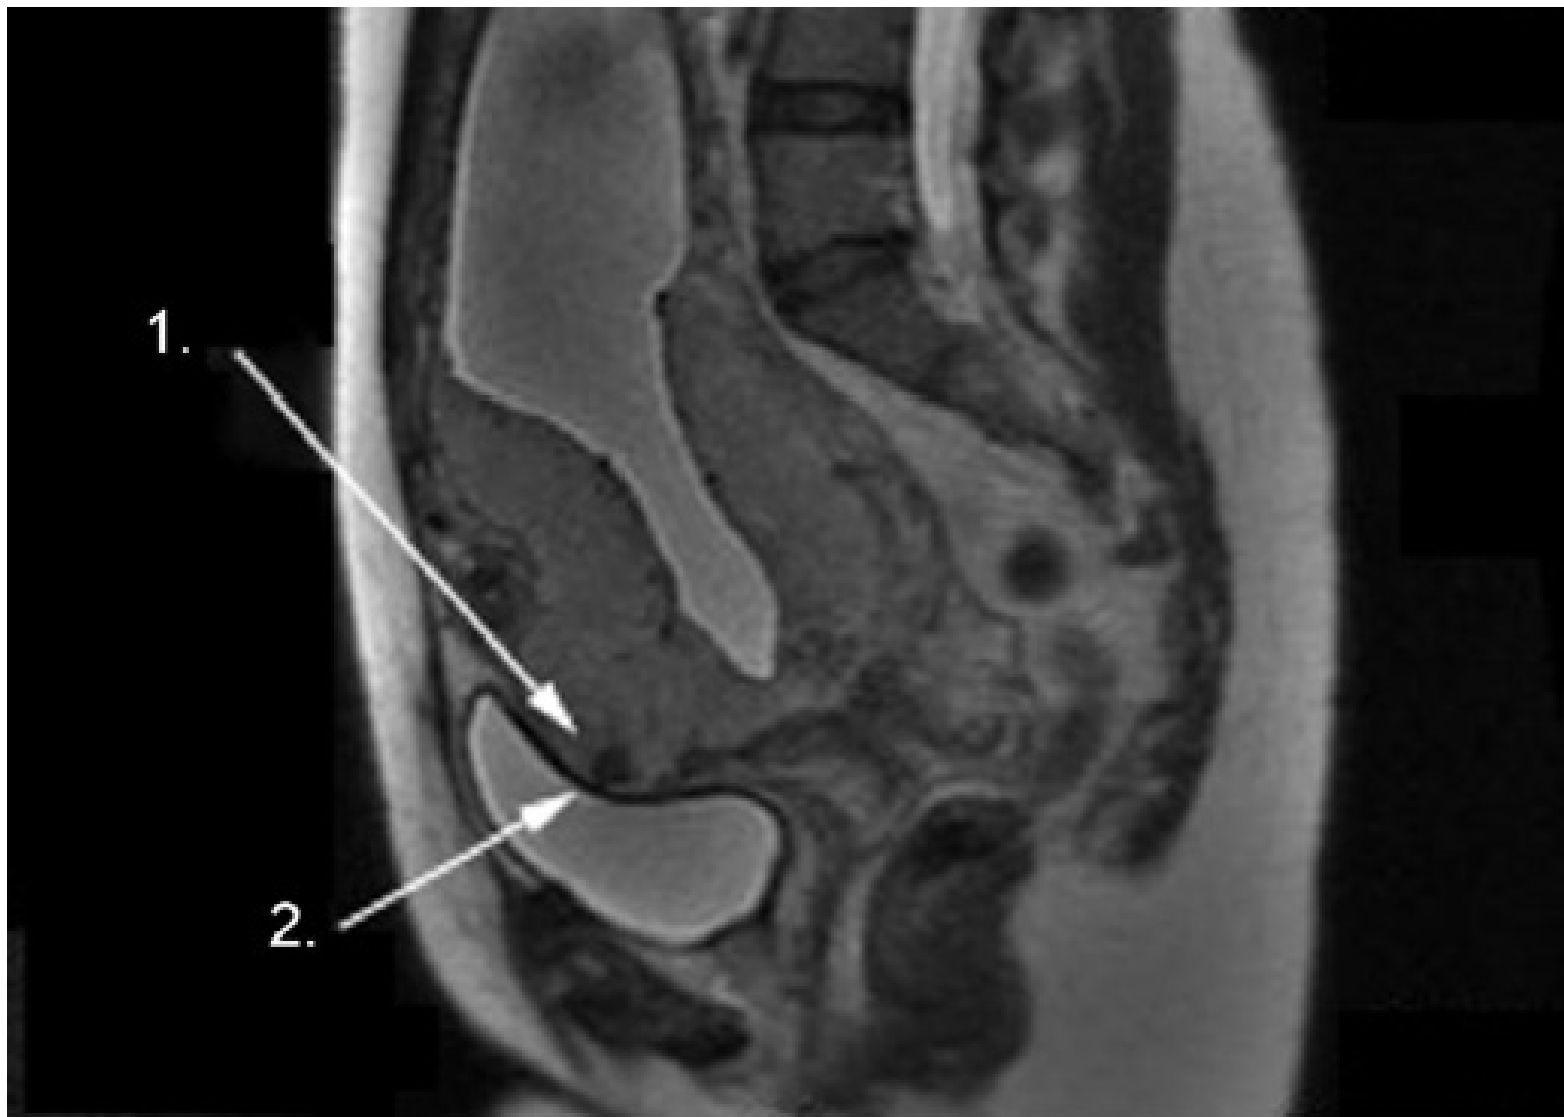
MRI view of pregnant uterus with placenta accreta. Note heterogeneous placenta with lacunae (1). Placenta bulges into upper bladder surface (2).
